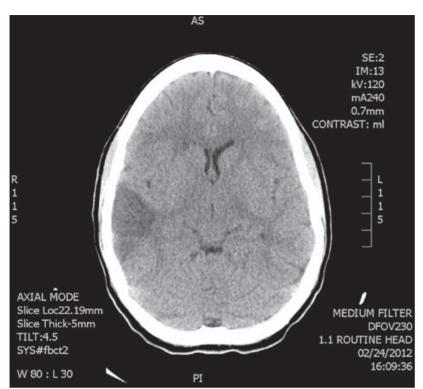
Computed tomography non-contrast of head revealing late acute to subacute middle cerebral artery cerebrovascular accident
